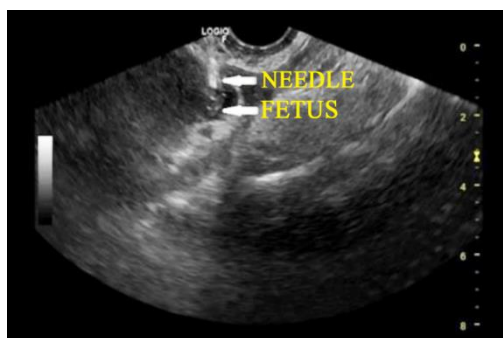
Transvaginal ultrasound guided intrafetal injection of KCL and methotrexate instillation
